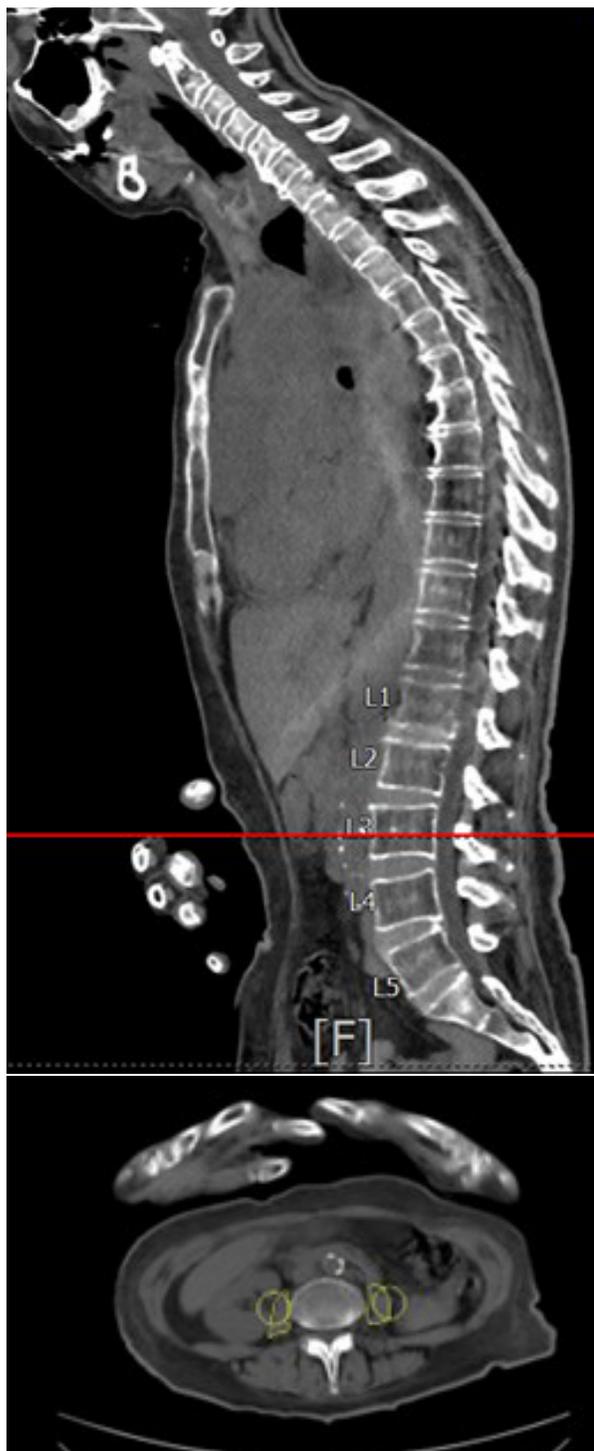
Measurement of the psoas muscle index using computed tomography at the L3 level.
